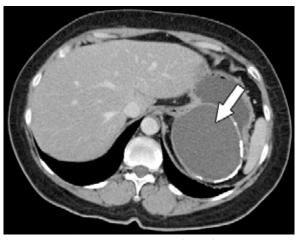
CT image shows a cystic lesion (arrow), measuring 8.8 cm \times 7.1 cm, at the cardio-oesophageal junction.
